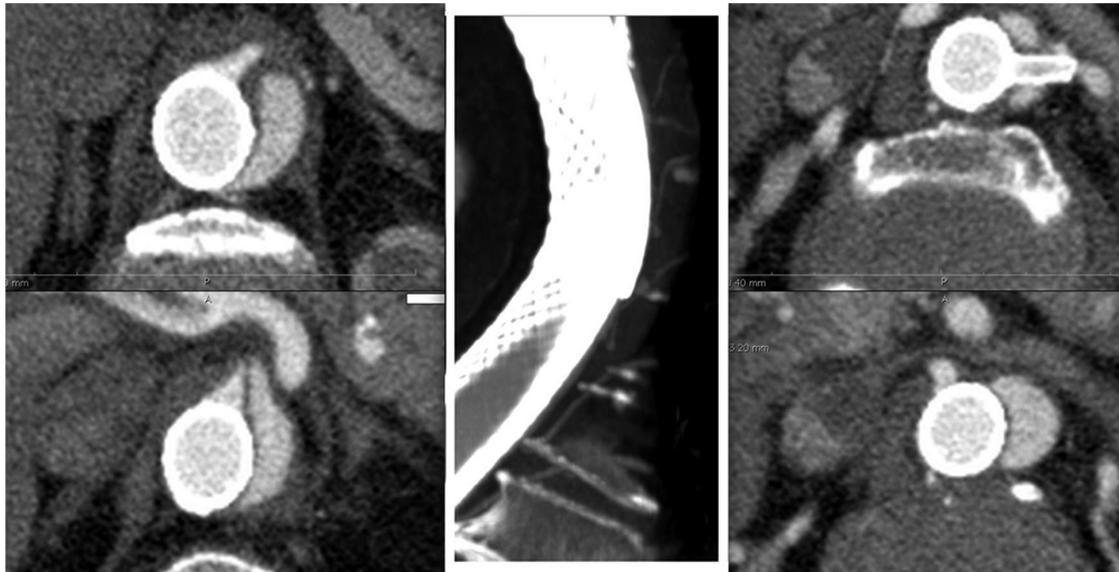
Postoperative CT-scan showing the visceral and intercostal arteries. Upper left: celiac trunk, bottom left: superior mesenteric artery whose origin is dissected, upper right: left renal artery stented for malperfusion in 2006, bottom right: right renal artery, middle: patent intercostal arteries. CT, Computed tomography.
